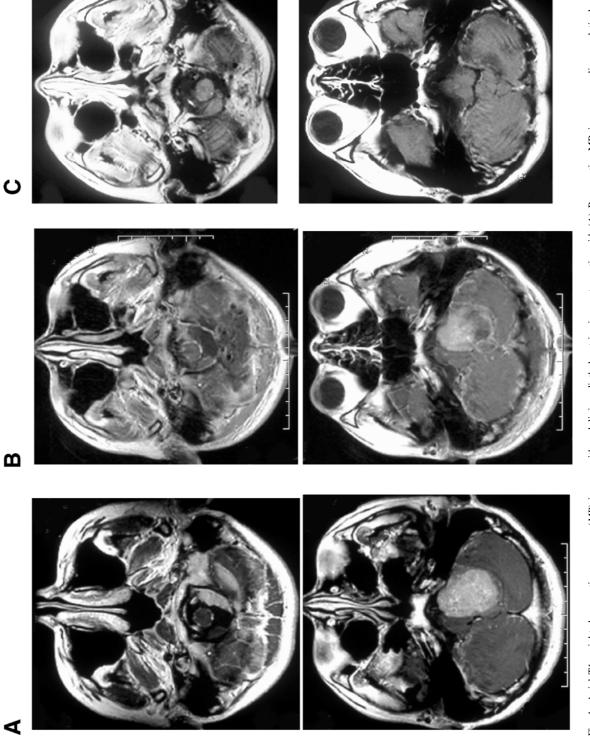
Axial T1-weighted magnetic resonance (*MR*) images with gadolinium-diethylenetriamine-penta-acetic acid. (A) Preoperative MR images revealing a relatively homo-geneously enhanced lesion in the left cerebellar hemisphere. (B) Postoperative MR images revealing residual tumour. (C) MR images 18 months after the surgery revealing disappearance of the tumour
